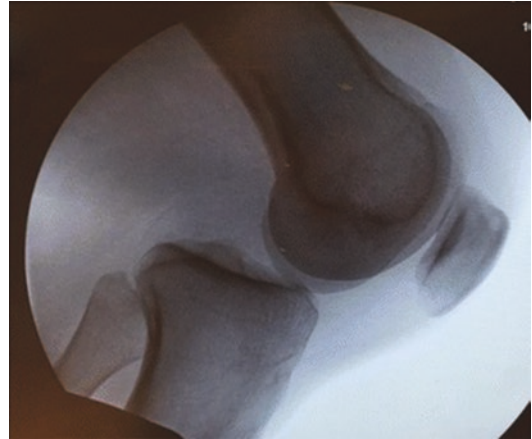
Lateral knee X-ray demonstrating increased posterior tibial translation with posterior drawer test performed. (Gill and Gwathmey [56])
